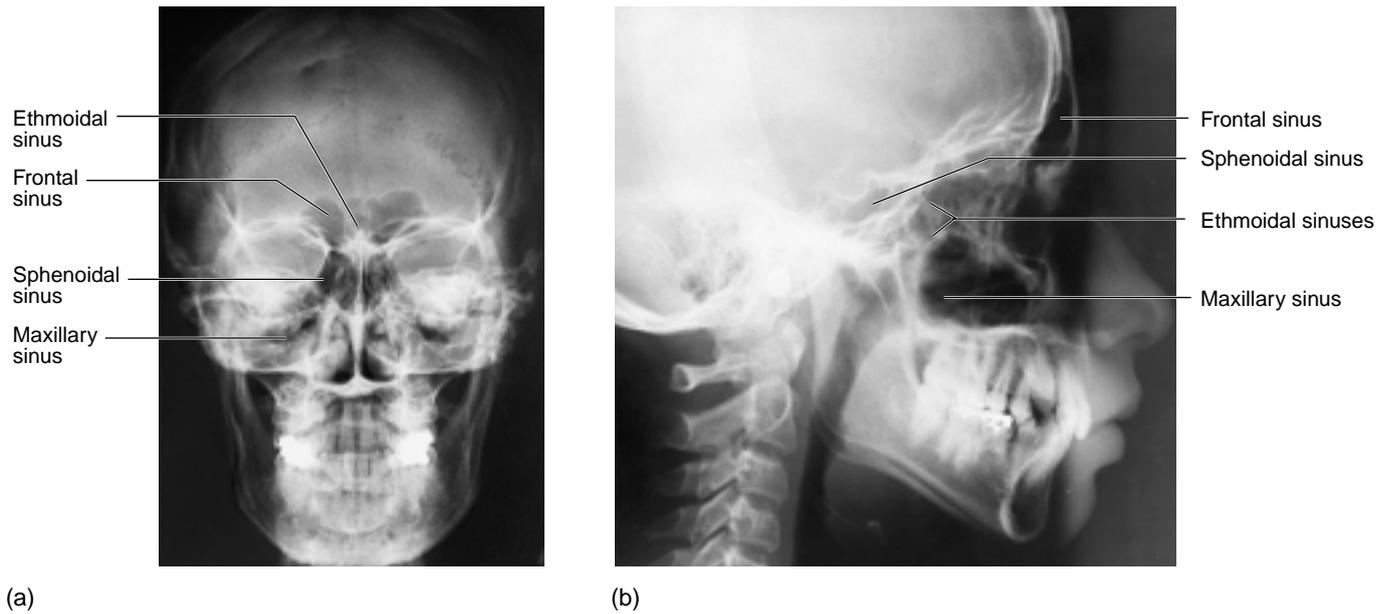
Radiographs of the skull showing the paranasal sinuses. (a) An anteroposterior view and (b) a right lateral view.
